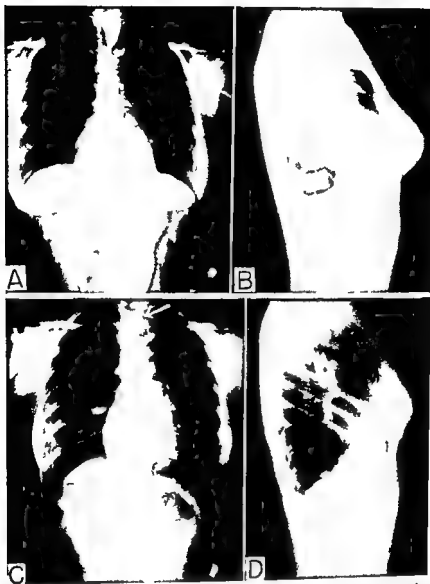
Roentgen films of a girl 17 years of age who swallowed lye solution with suicidal intent. *A B* Preoperative esophagograms showing the tremendous extent of the injury. *C and D* frontal and lateral views of barium in the colon segment transplanted to the anterior mediastinum for esophageal substitution. Anastomosis high in the neck (arrow)
